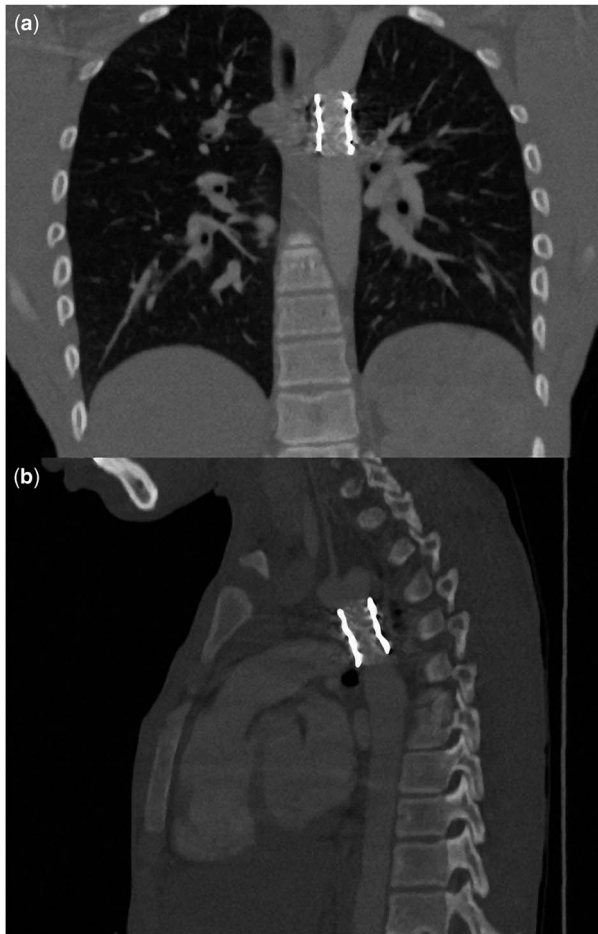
Thoracic multi-detector computed tomography images of a 13-year-old boy with recoarctation after stent implantation. Coronal view (a) and sagittal view (b). Restenosis, migration, and apparent fractures and aneurysms cannot be seen.
